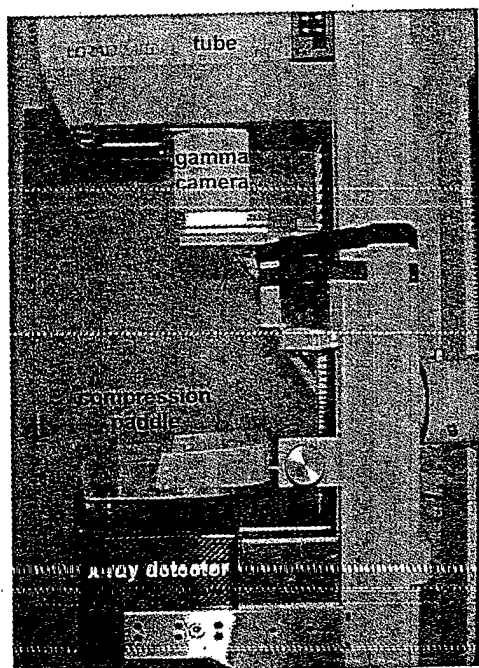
Dual modality scanner now under clinical evaluation at the University of Virginia. The gamma camera is raised to the location shown for the X-ray image, then lowered to a position immediately above the compression paddle for acquisition of the gamma image.
